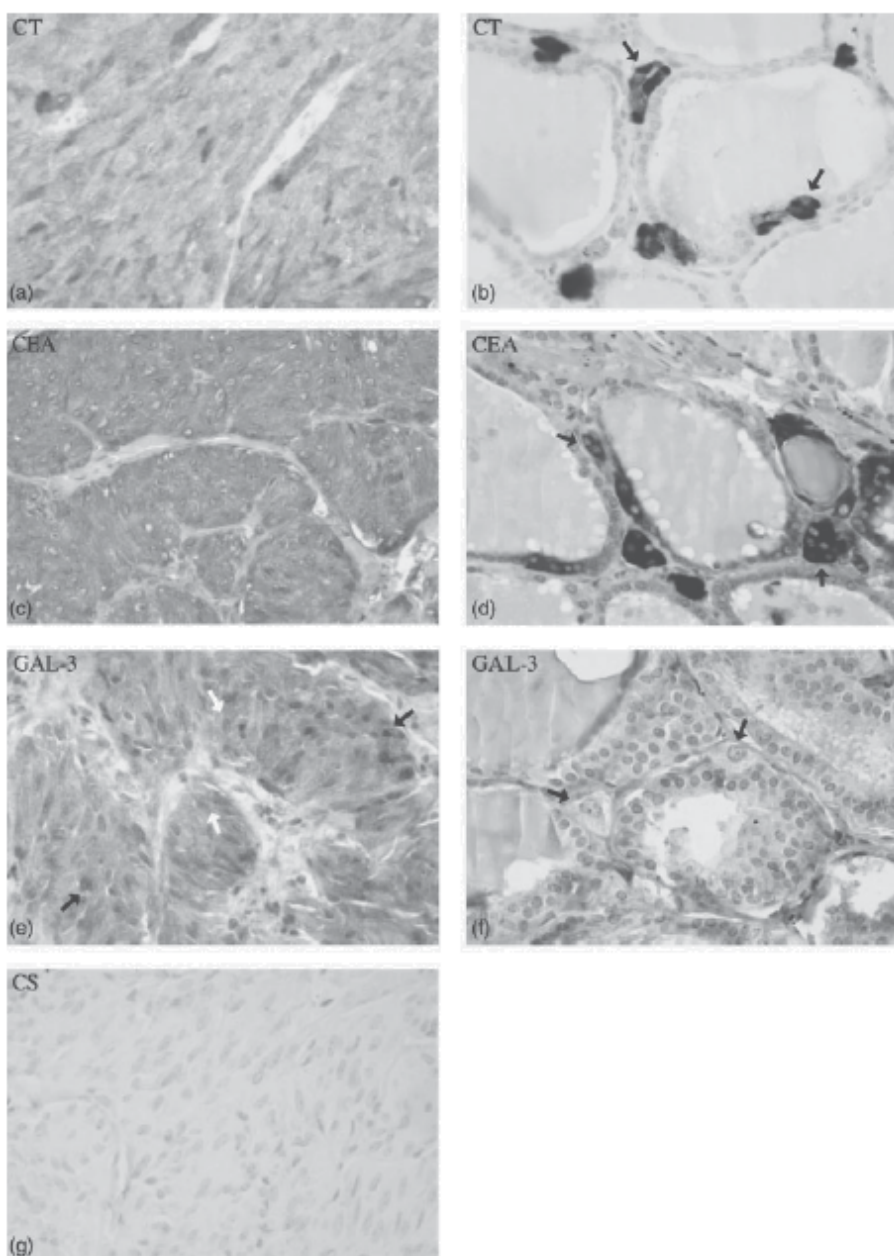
Expression of calcitonin (CT), CEA and GAL-3 in medullary thyroid cancer (MTC) and C-cells hyperplasia (CCH). Photos a, c, e, g represent a MTC case: CT, CEA and GAL-3 are diffusely expressed in tumor tissue at the cytoplasmatic level. Some tumor cells also display GAL-3 positivity at the nuclear level (black arrows). The specificity of anti-GAL-3 antibodies is demonstrated by negativity in control sections (CS) of the same tumor. Photos b, d, f represent a CCH case: CT and CEA are strongly positive and GAL-3 is negative in large C-cells (from Faggiano et al., 2002).
